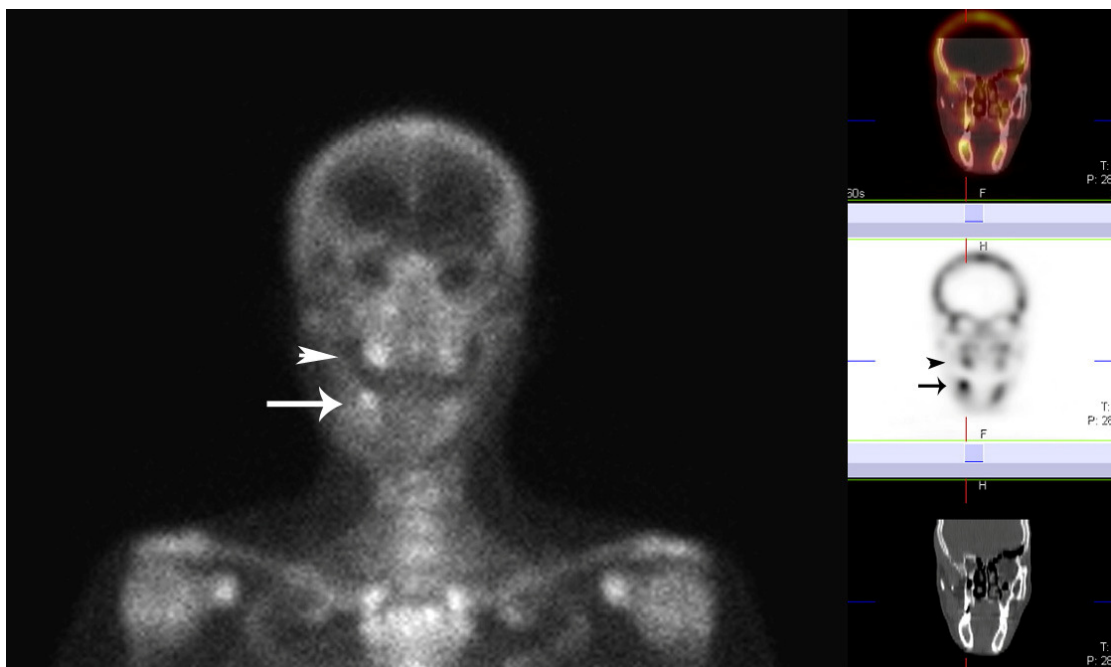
Planar and SPECT/ CT images of the head show focal increased osteoblastic activity in the mandibula (arrow) and maxilla (arrowhead).
